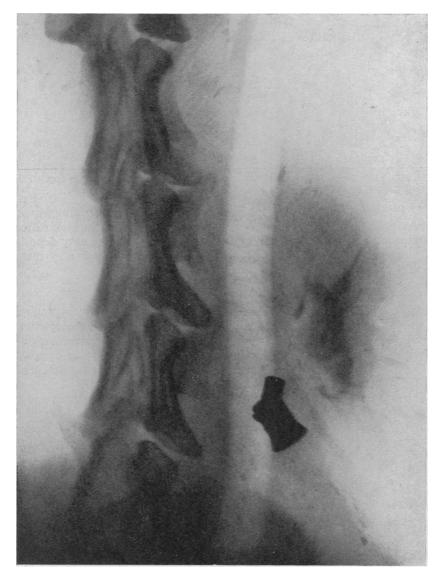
A photograph of an X-Ray taken 12 minutes after injection of 35 per cent. pyelosil. The Blakemore-Lord tubes are clearly visible.
